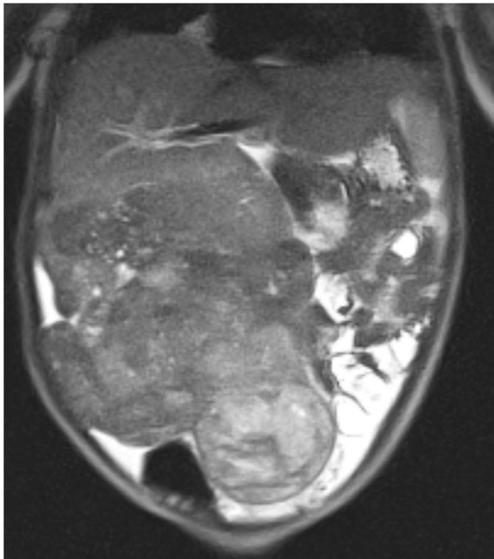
Coronal T2-weighted MRI in a child with hepatoblastoma shows a pedunculated tumor extending from the inferior aspect of the segments 5 and 6. This is a PRETEXT II tumor
